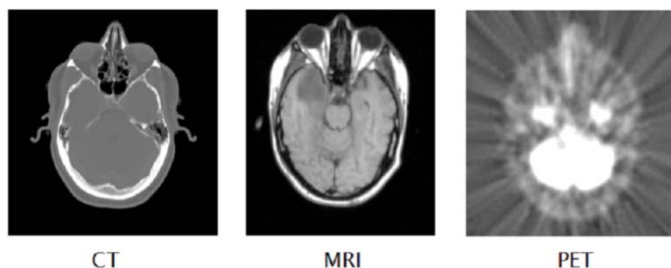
Examples of brain CT, MRI, and PET images. Note that the appearance of the anatomy varies with acquisition method.
